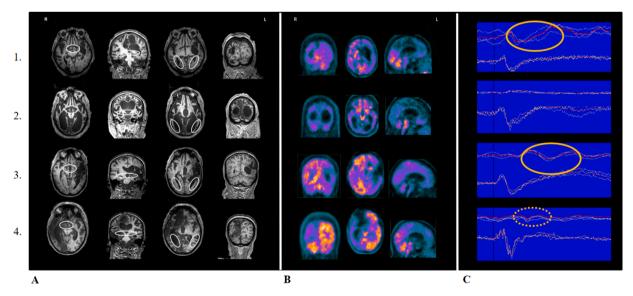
Patients with visual fixation: MRI, FDG-PET, and fVEPs data. Each row corresponds to a single patient showing visual fixation (from 1 to 4 on y-axis). Both MRI and FDG-PET images have been selected from those most representative. (A) The panel shows the MRI data of the retrochiasmatic structures; each circle highlights the optic tracts (1st column), lateral geniculate body (2nd column), optic radiation/primary visual cortex (3rd column), and the visual cortex (V1-V2/V8; 4th column) in the four patients showing visual fixation. (B) The panel shows the metabolic activations derived from FDG-PET data in the four patients showing visual fixation. (C) The panel shows the visual evoked potentials (VEPs) at Oz-Fz (upper traces) and electroretinograms of the four patients showing visual fixation. Red lines represent grand averages of three different averages (yellow lines). Orange circles highlight the VEPs obtained in patients 1, 3, and (albeit largely abnormal) 4. Patient 2 showed no cortical response to flash.
